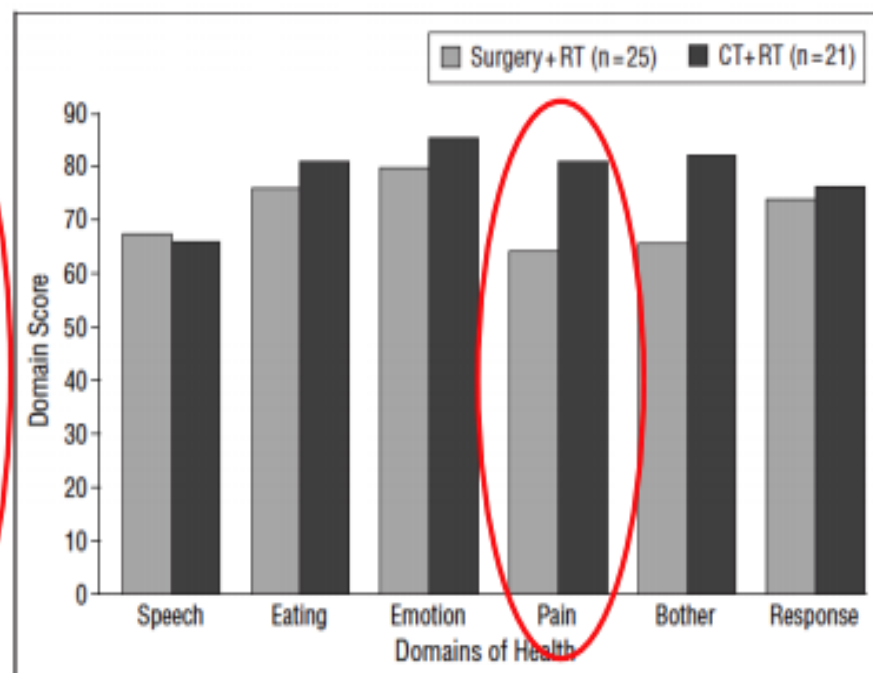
Comparison of health status for surgery and radiation therapy (RT) vs chemotherapy (CT) + RT patients for 6 domains of the Head and Neck Quality of Life (HNQOL) instrument. Response indicates the treatment item of HNQOL; bother, the overall bother item on the HNQOL. $P < .05$ for pain.
